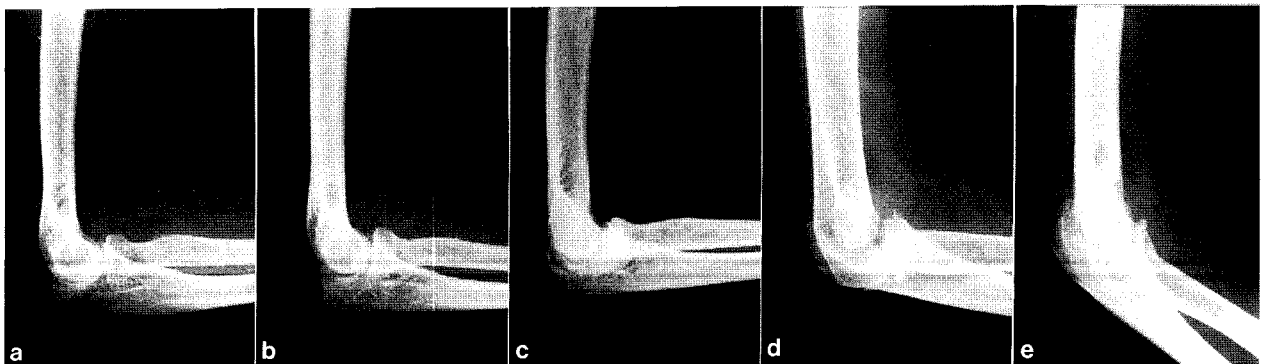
Lateral X-rays of rheumatoid elbows used as standards for Larsen's X-ray evaluation. a: Grade 1; b: Grade 2; c: Grade 3; d: Grade 4; e: Grade 5.
